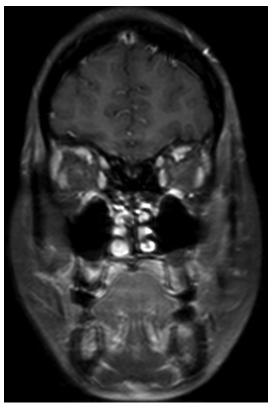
Coronal T1-weighted post-contrast MRI of the brain showing mild enhancement of the left optic nerve.
